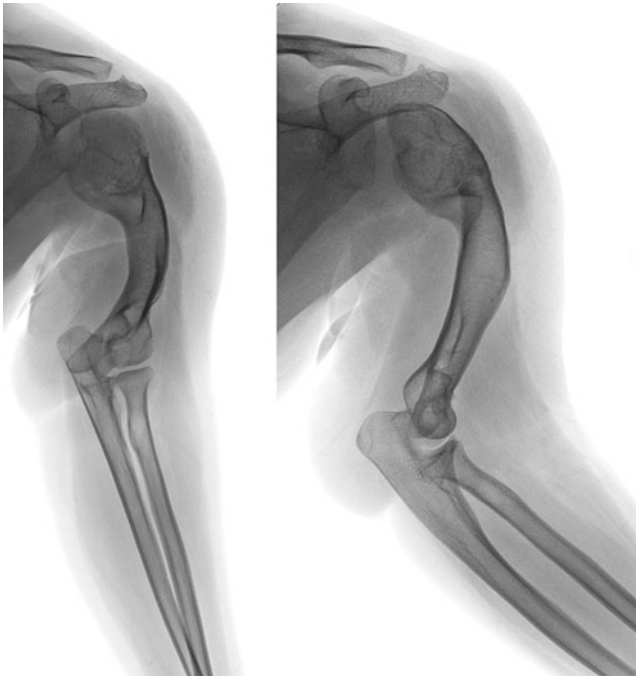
Preoperative AP and LAT radiographs of the humerus demonstrating significant distortion of the glenohumeral joint and proximal humerus. Note varus-procurvatum deformity (40°) of the humeral diaphysis (asymptomatic) and the severe (15 cm) shortening
